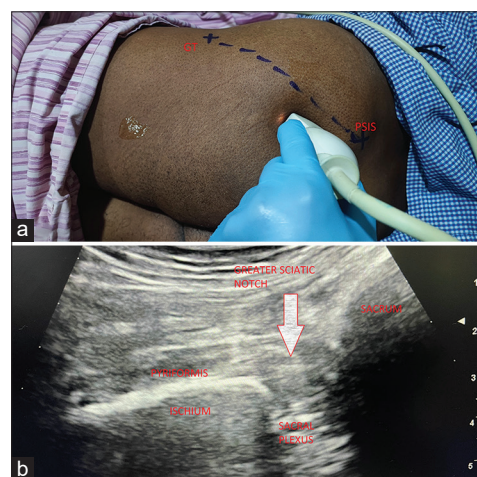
(a) Curvilinear probe is moved inferomedially (parasacral parallel shift). (b) Corresponding ultrasound picture showing greater sciatic notch, ischium, and sacral plexus
